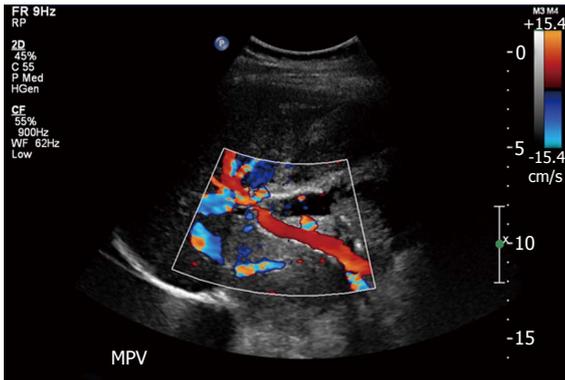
Post-operative Doppler ultrasound of the liver demonstrating widely patent portal vein with normal direction of blood flow. MPV: Main portal vein.
